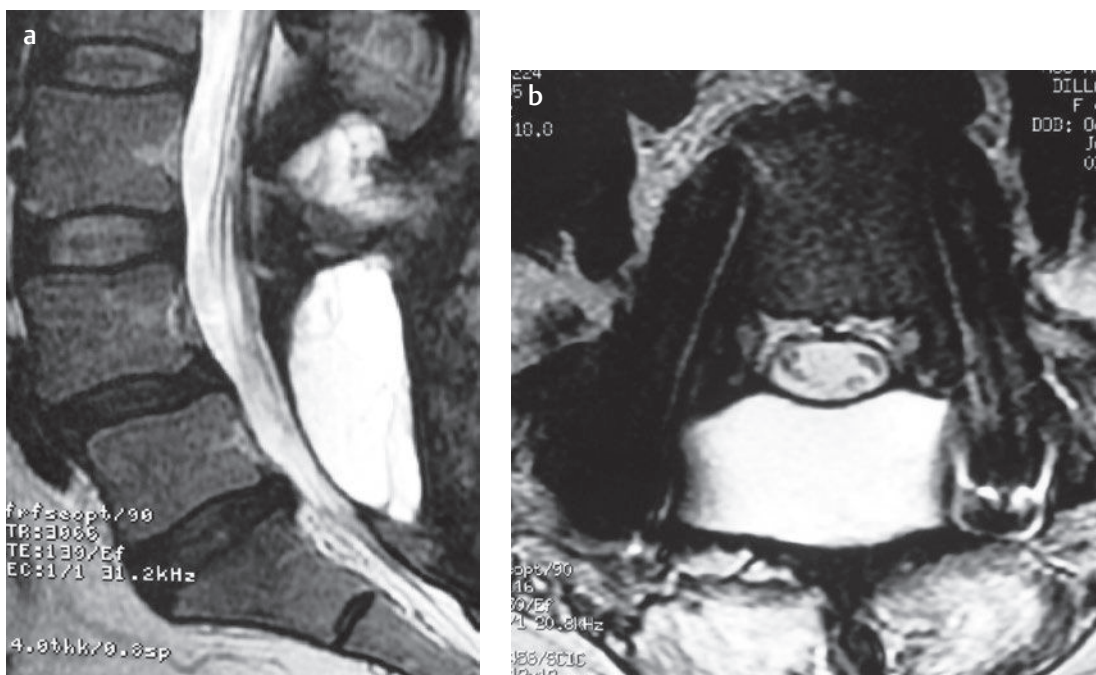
Pseudomeningocele. (a) Sagittal and (b) axial T2-weighted images of a patient who sustained a durotomy during revision L4-S1 laminectomy and instrumented posterior fusion. The images show a well-circumscribed fluid collection that does not compress the thecal sac. Note that on (b) the axial image at the L5 level, the central canal can be well visualized in the presence of pedicle screws.[†]
